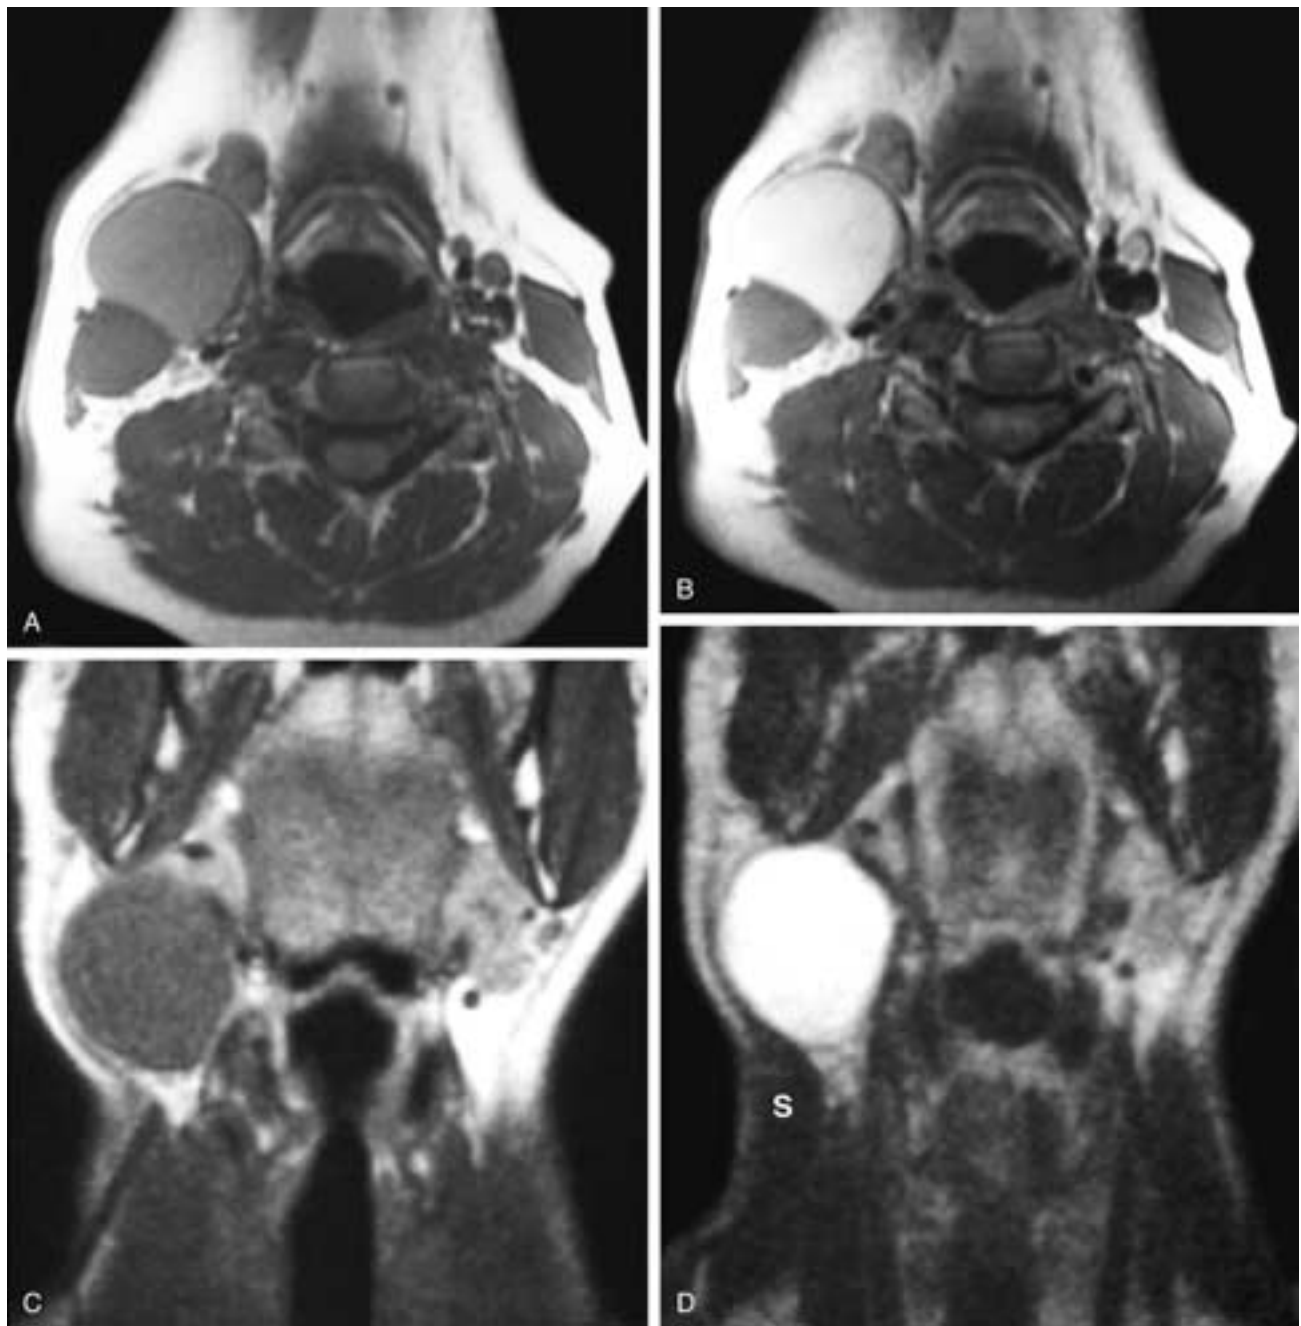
Axial T1-weighted (A) and T2-weighted (B) MR images show a spherical mass in the right neck that is lateral to the carotid sheath structures, behind the submandibular gland, and along the anterior margin of the sternocleidomastoid muscle. This second branchial cleft cyst has fairly low T1-weighted and high T2-weighted signal intensity. If contrast had been given, the cyst wall could have been differentiated from the cyst fluid. Coronal T1-weighted (C) and T2-weighted (D) MR images show a right-sided spherical mass with low T1-weighted and high T2-weighted signal intensity. This mass is just caudal to the mandible and just deep to the sternocleidomastoid muscle (S). Second branchial cleft cysts such as this one may have low to high T1-weighted signal intensity and almost always have high T2-weighted signal intensity. Without contrast, the cyst wall is rarely seen.
